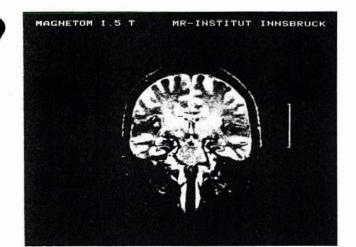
T2 weighted MR images of the brain (A) and lumbosacral spine (B) in a 59-year-old patient with a symptomatic form of superficial siderosis of the CNS. The coronal screen (A) through the temporal lobes shows signal loss of the cortical surface in the insular region, the mesiobasal temporal lobes, the brain stem and spinal cord. The sagittal image (B) of the lumbosacral spine revealed a tumor extending from L5 to S5 with widening of the spinal canal and signs of previous hemorrhage (arrow).
